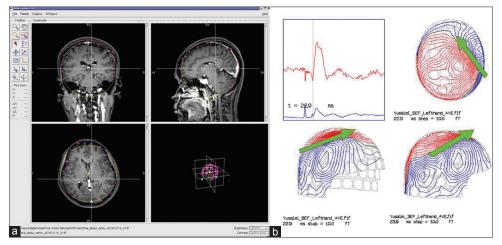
(a) Magnetoencephalography (MEG) registration and fusion: MEG data were processed and fused with anatomical magnetic resonance images. (b) Equivalent current dipole method for MEG source localization for magnetic evoked response to localize the eloquent cortex
